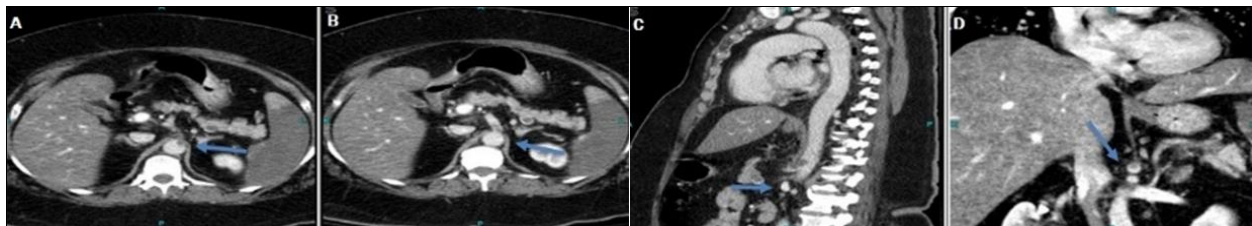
CT scan of the abdomen showing filling defect in the origin of celiac axis extending in the celiac trunk (celiac artery thrombosis) shown with blue arrow in A, B, C and D
